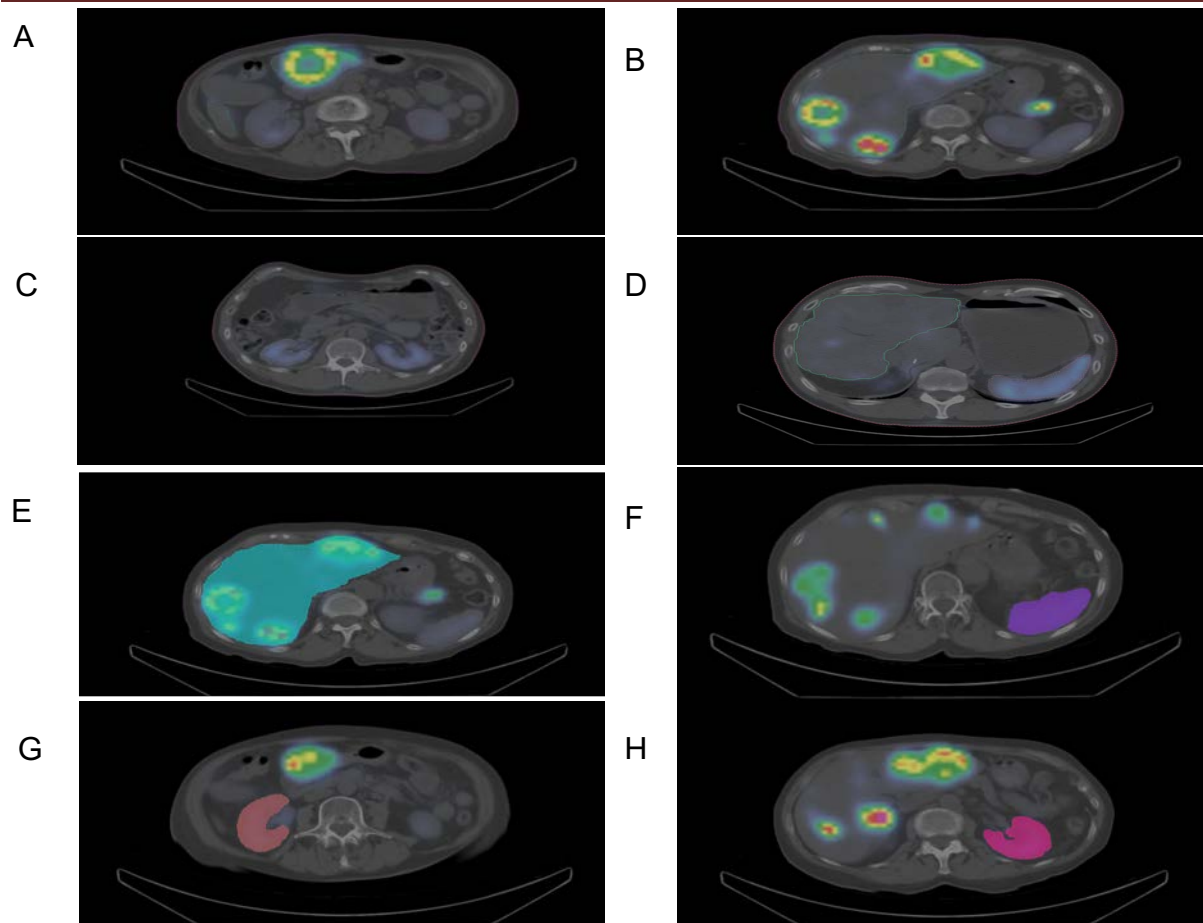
Axial slices showing segmented organs in the reference CT, using PDOSE workstation. A, B: female patient first treatment cycle, C, D: male patient first treatment cycle. For female patient E: liver, F: spleen, G: right kidney, H: left kidney. Own creation. Patient image provided by ICM nuclear medicine department.
